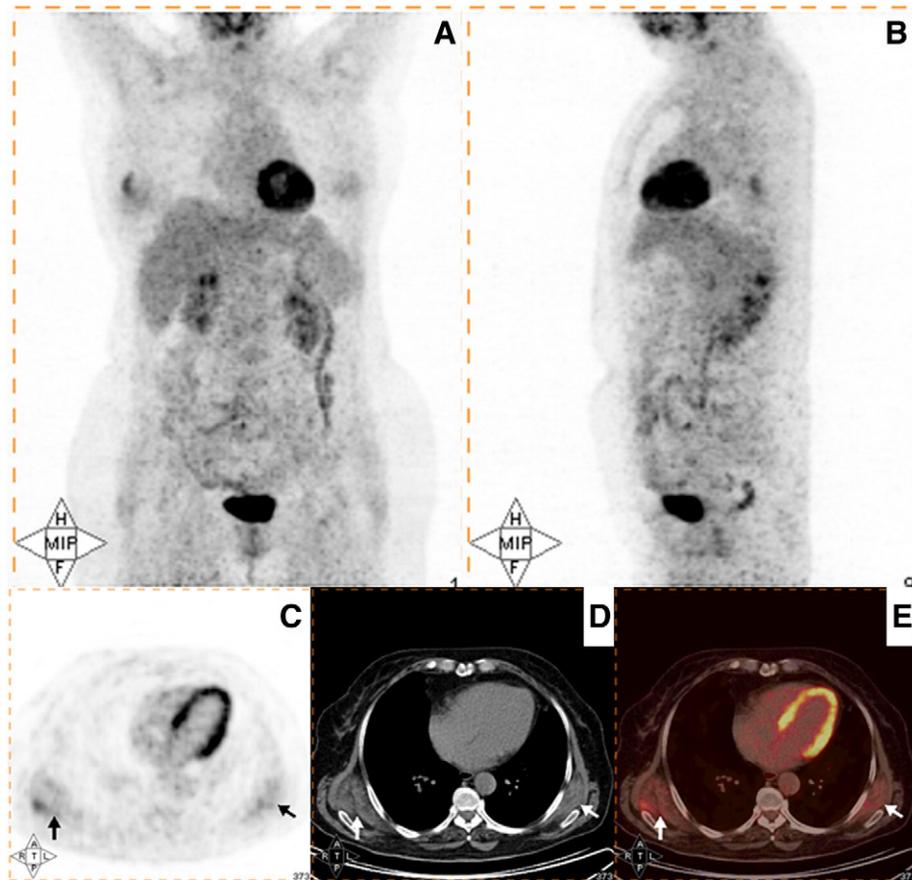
An 83-year-old female patient with health examination. (A) A frontal MIP image of PET shows abnormal ¹⁸F-FDG uptake in the bilateral posterolateral chest (arrows); (B) A lateral MIP image of PET shows abnormal ¹⁸F-FDG uptake at the posterior part of the chest (arrows); (C) Axial PET image shows mild ¹⁸F-FDG uptake in bilateral posterolateral chest (arrows); (D) Axial CT image shows crescent-shaped soft-tissue masses in both subscapular lesions (arrows); (E) On fused PET/CT image, area of mild hypermetabolism corresponds to the soft-tissue masses (arrows). SUVs were 2.8 in the right mass and 2.3 in the left.
